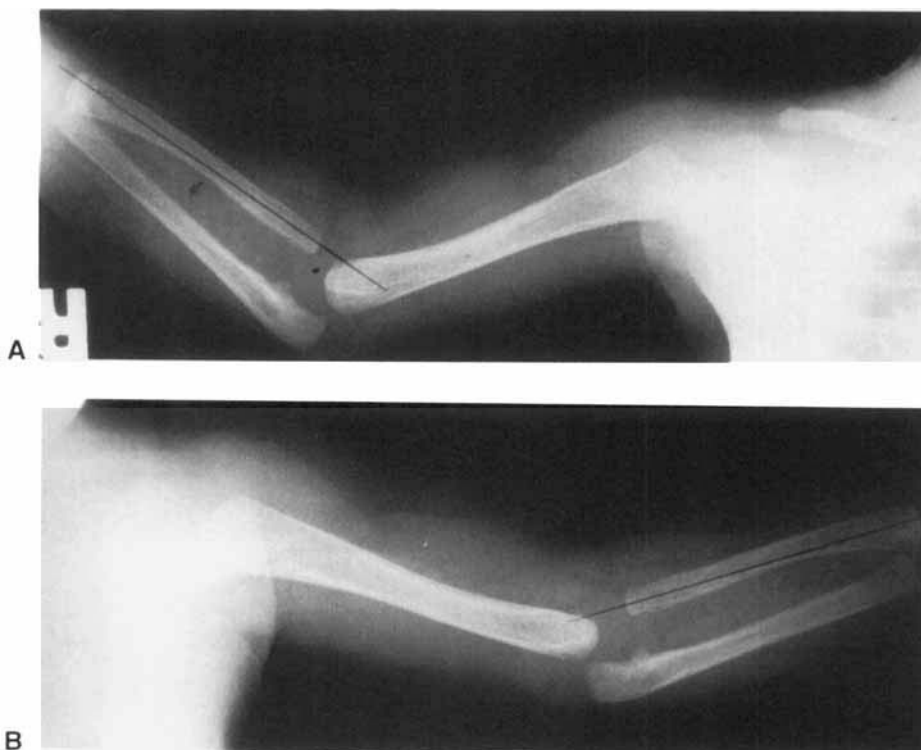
A: Right upper limb radiograph, and (B) left upper limb radiograph demonstrating dislocation of the radial heads with abnormal ulnae and flattened olecranon fossae, bilaterally.
